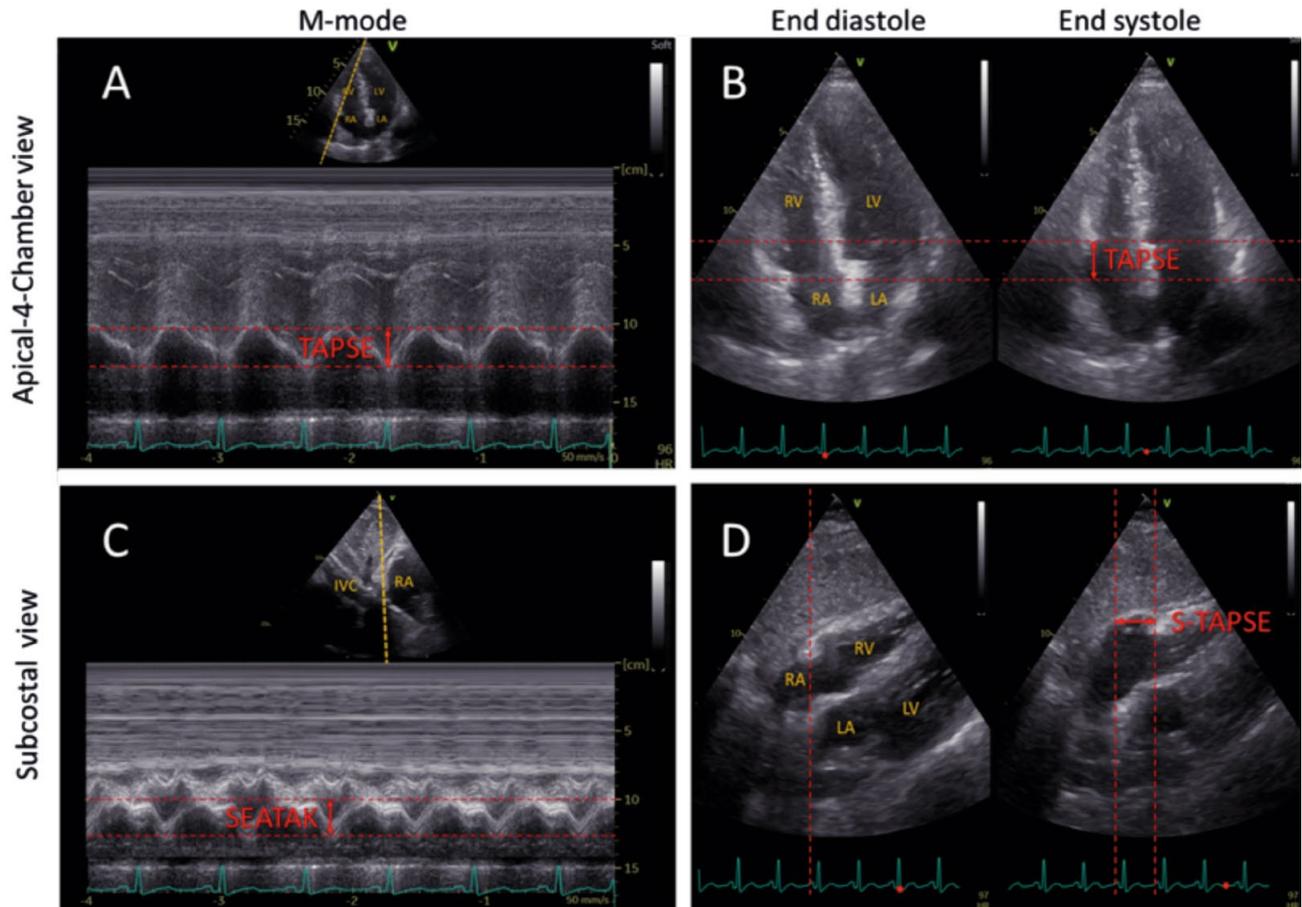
Measurement of tricuspid annular plane systolic excursion (TAPSE), subcostal echocardiographic assessment of tricuspid annular kick (SEATAK) and the subcostal-TAPSE (S-TAPSE)
